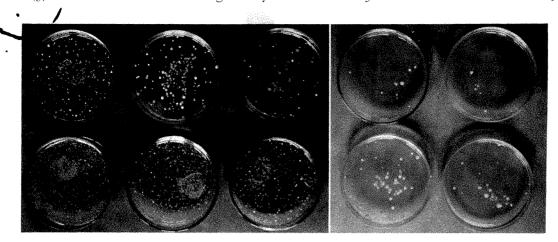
Agar plate cultures of Saccharomyces cerevisiae showing different dilutions and the growth following varying exposures to radiation. The plates in the upper row had an original concentration one-tenth that of the ones in the lower row. Going from left to right the plates in both rows received respectively 0, 8, 16, 32, 64 and 128 minutes' exposure to roentgen rays (390 r/min.). Three significant things may be noted: (1) that the colonies in the more densely populated dishes are smaller whether receiving radiation or not; (2) that the colonies appear to be unaffected by the irradiation and (3) that the number of colonies present becomes less as the dosage of radiation administered is increased.
